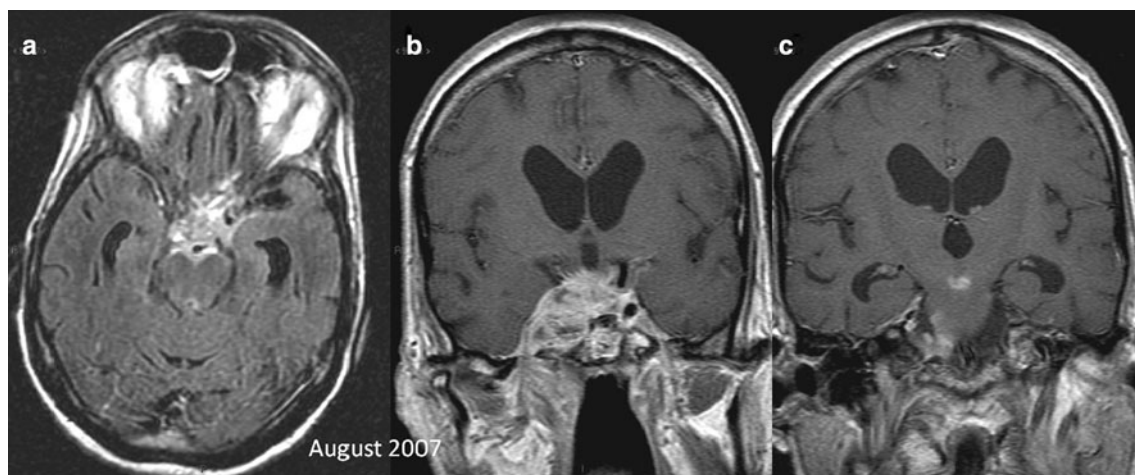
MR work-up in August 2007: post-contrast axial transverse (a) and coronal T1-weighted images (b) showing progression of hyperintense and enhancing mass of the skull base with meningeal
